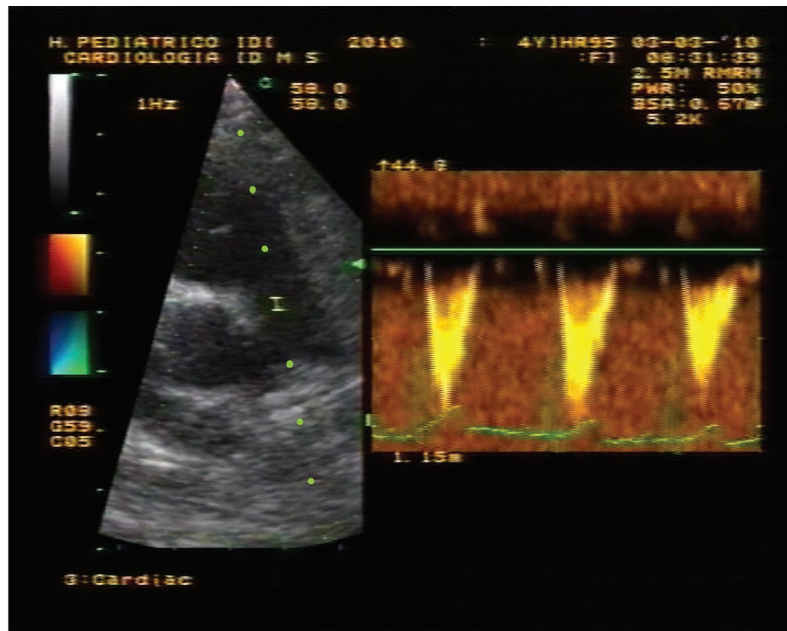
On the left, a 2D image showing the placement of the Doppler sample (dot line) and on the right, Doppler frequency shift waveforms.
